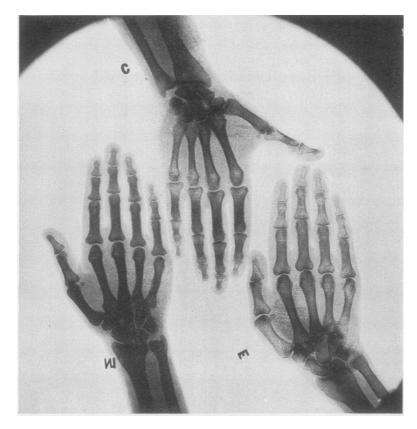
SINGLE X-RAY OF THE HANDS OF THREE WOMEN OF SIMILAR AGE, SIZE AND WEIGHT
